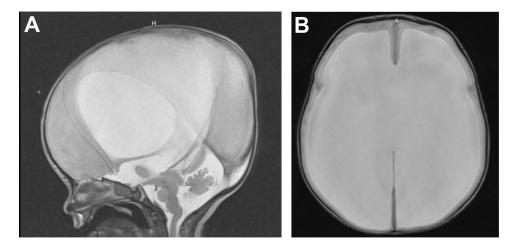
1-day-old with L1 syndrome resulting in hydrocephalus and aqueductal stenosis treated on day-of-life 1 with a VP shunt. T2-weighted MRI (A) sagittal and (B) axial views.
